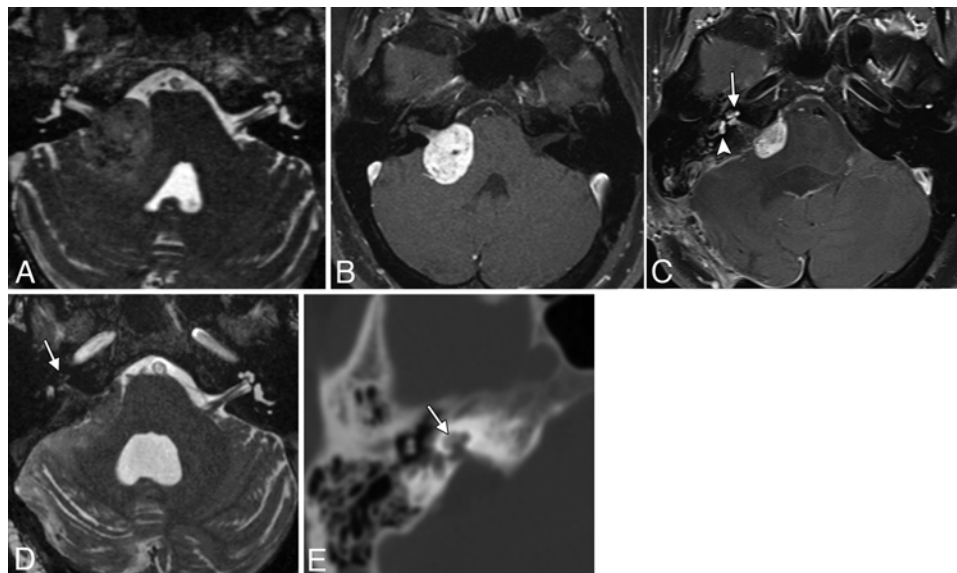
Labyrinthitis. A and B: Preoperative postcontrast fat-suppressed axial T1-weighted MRI study (A) and CISS sequence (B) showing a right vestibular schwannoma with preservation of the endolymphatic fluid signal and no abnormal labyrinthine enhancement. The patient developed postoperative *Klebsiella* meningitis. C: Postoperative postcontrast fat-suppressed axial T1-weighted MRI study showing subtotal resection of the tumor and new avid enhancement in the cochlea (arrow) and vestibule (arrowhead). D: Corresponding CISS sequence showing loss of the fluid signal in the right cochlea (arrow). E: Axial CT image obtained 1 year later showing hyperdensity within the cochlea (arrow), consistent with labyrinthitis ossificans.
